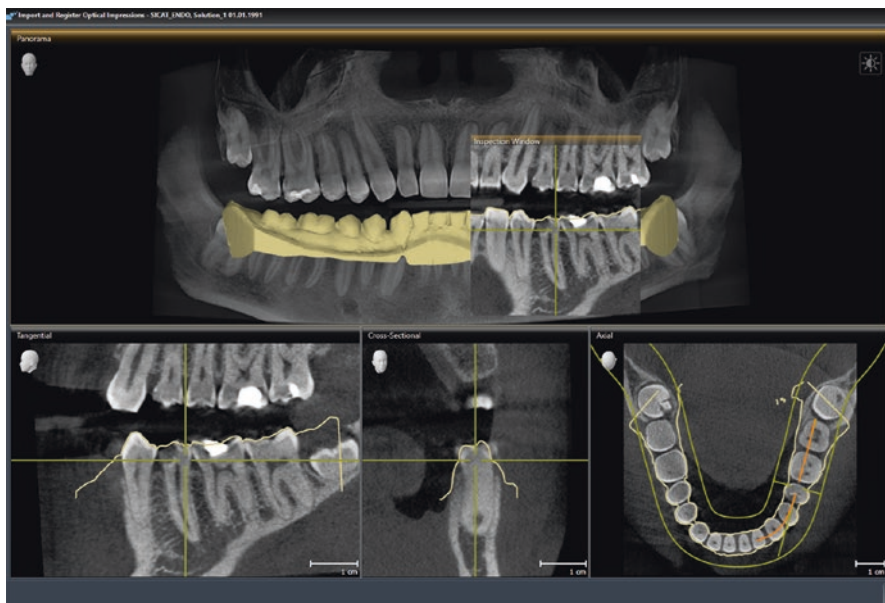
Accuracy and adaptation of the CBCT 3D reconstruction and the 3D reconstruction from an optical impression can be visualized by adjusting transparency layers. The yellow lines show data from the optical impression. Images from SICAT Endo® (SICAT, Bonn, Germany)
